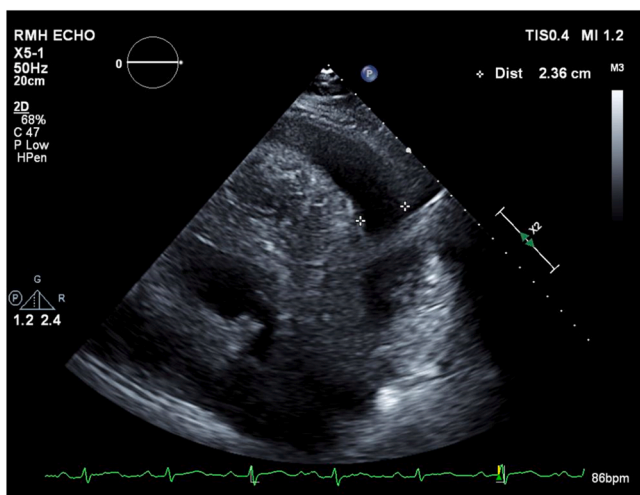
Transesophageal echocardiogram (TTE): large circumferential pericardial effusion without tamponade physiology. Posteriorly, the effusion measure was 2.43 cm, and anteriorly, it was 1.43 cm.
